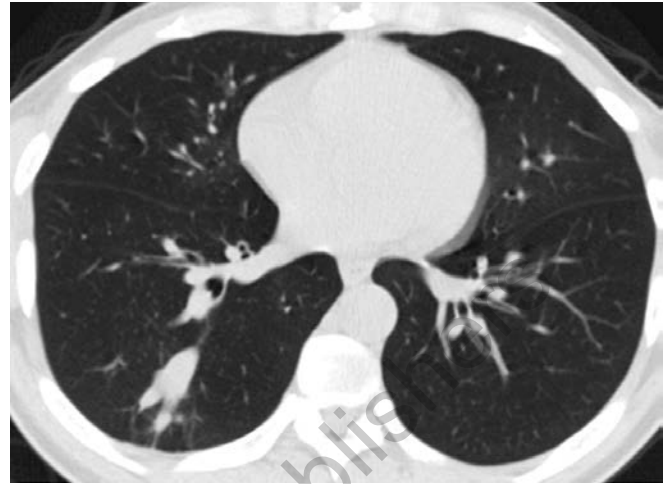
CT chest in a patient with allergic bronchopulmonary aspergillosis showing inspissation of the lower lobe bronchi
